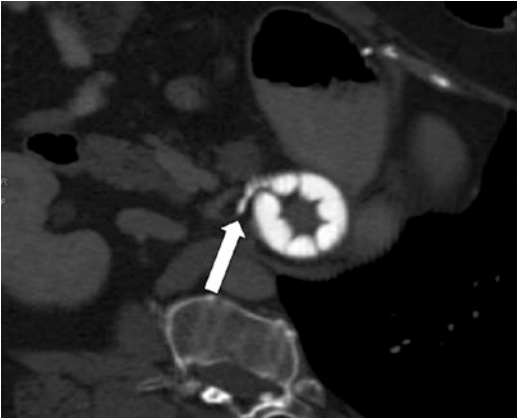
Axial-oblique CT reformat with maximum intensity projection showing normal appearances of a band filled with iodinated contrast. Note the smooth outer contour and lobulated inner margin and the locking device, which holds the band in a closed loop (*arrow*)
